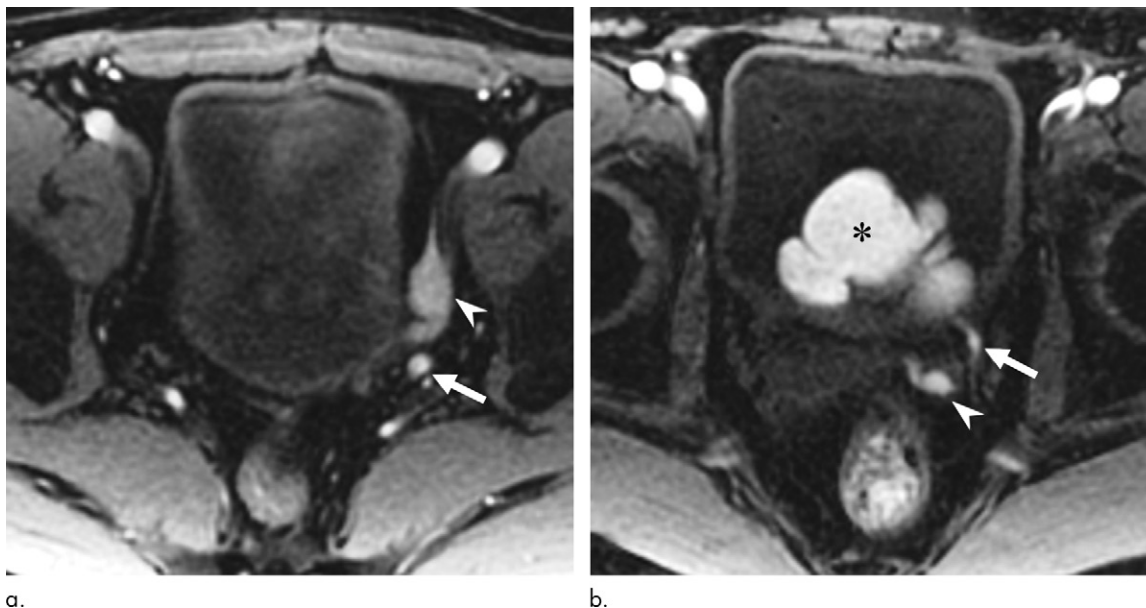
Images from (a, b) unenhanced axial fat-saturated T1-weighted (6.2/3.1) MRI show the left ureter (arrow), left vas deferens (arrowhead in a), left seminal vesicle (arrowhead in b), and cecoureterocele (*).
